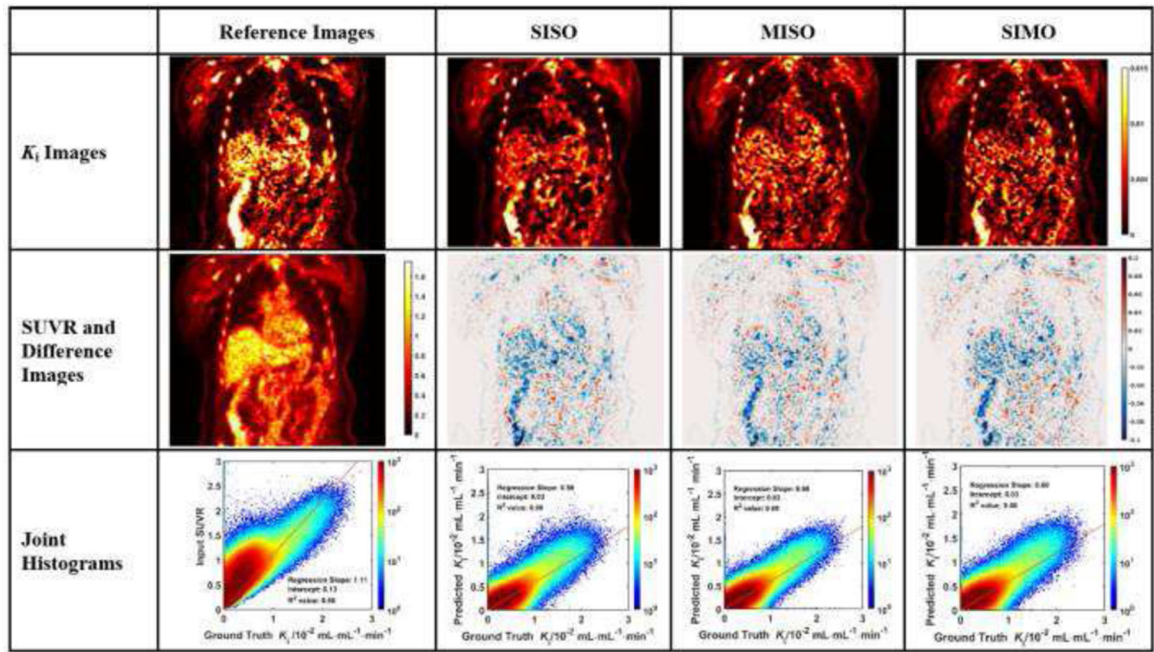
Evaluation analysis of sample subject #3 including the synthetic and reference K_i images, corresponding difference images, SUVR input image, and the joint histograms. In each joint histogram, the regression line was represented by the red straight line, with labels of regression slope, intercept and R^2 value.
